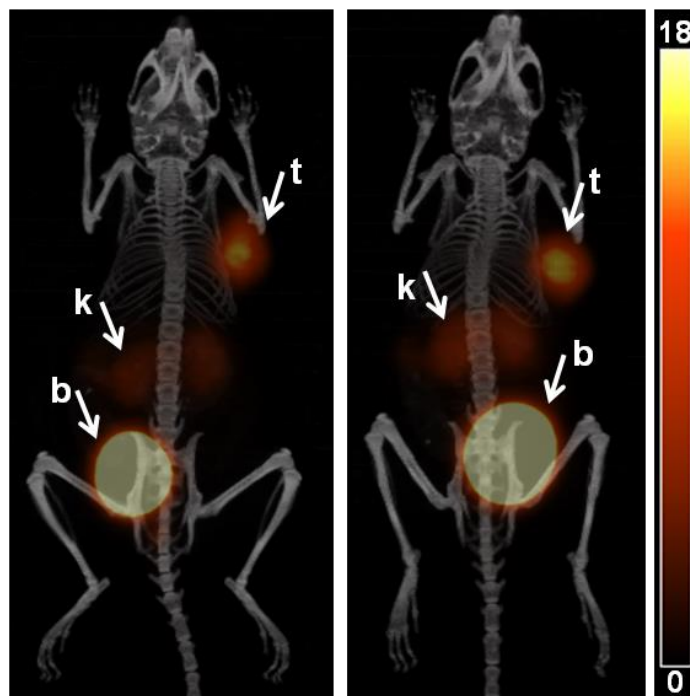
Representative maximum projection PET images fused with CT of DOTA-TOC radiolabeled with ^{68}Ga either from the generator (left) or the cyclotron (right). ZR75-1 tumours (t) are visible on the right shoulder as well as kidney (k) uptake and bladder (b), scale bar indicates %ID/g.
